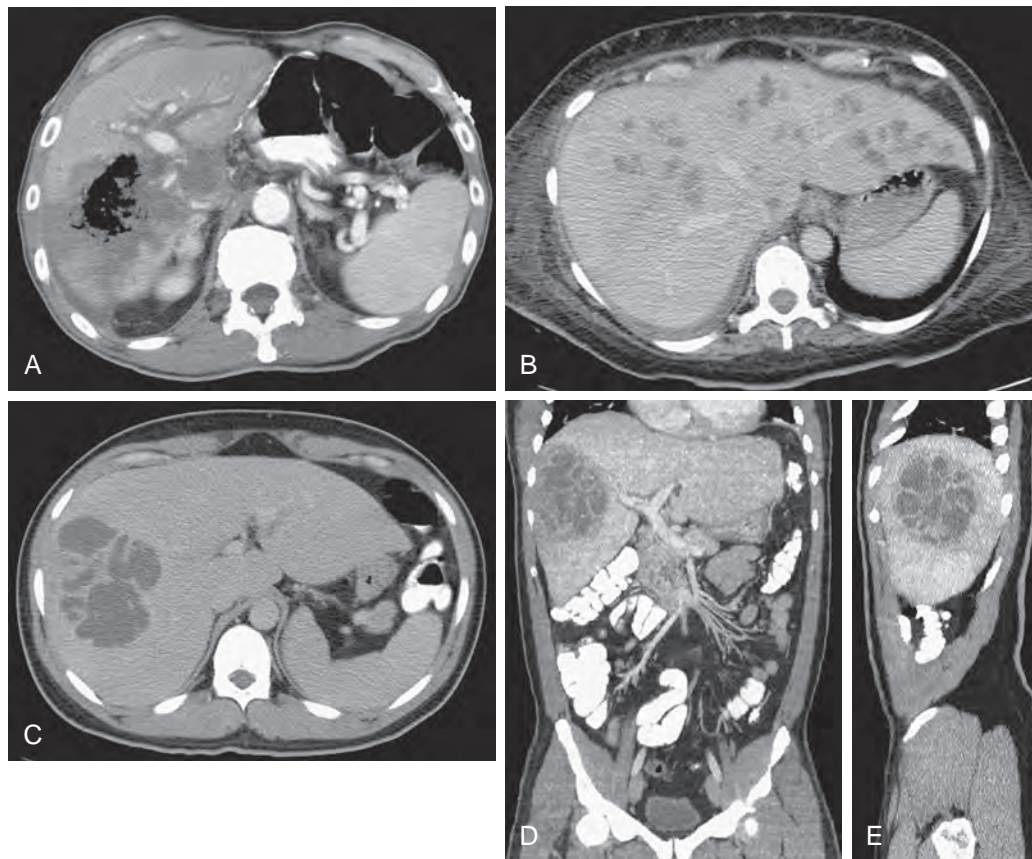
Pyogenic liver abscess: CT findings. A. Mottled gas collection is present in this right lobe abscess. B. A multifocal abscess is identified in this patient with cholangitis. Axial (C), coronal (D), and sagittal (E) images show the classic cluster sign of a multiloculated pyogenic liver abscess. Note the peripheral lobulations and thin enhancing wall.
